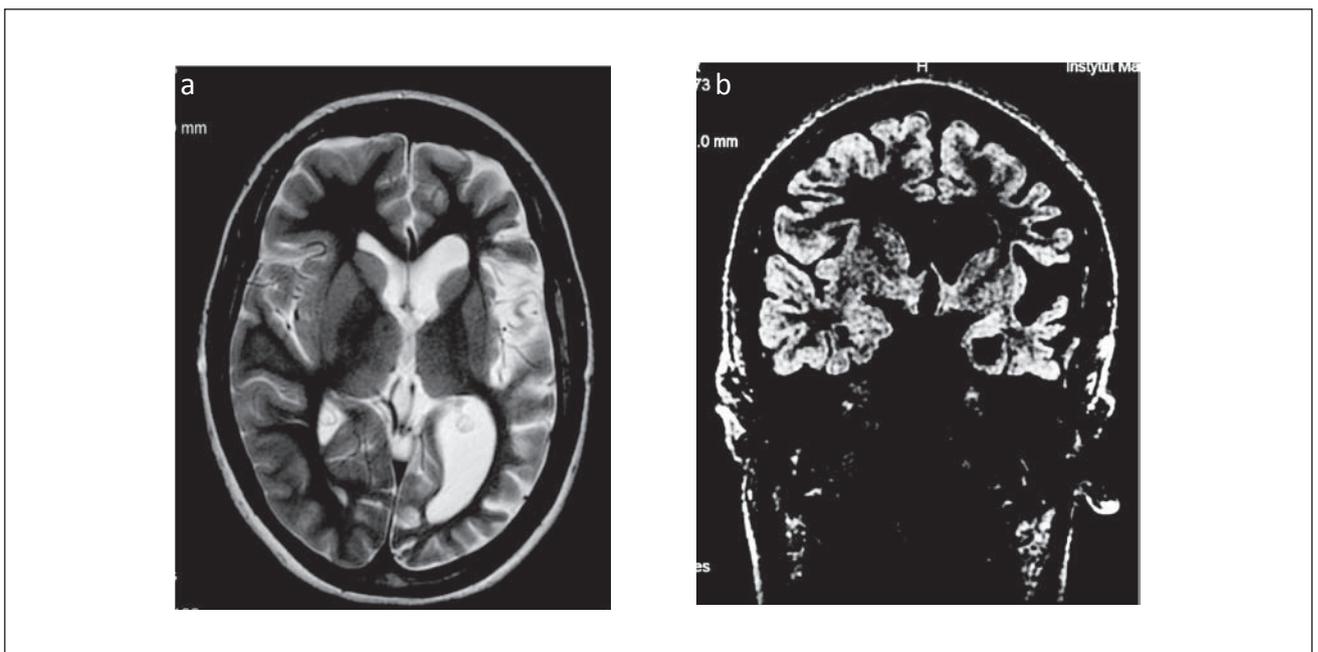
Brain MRI at the age of 12 – progression of the changes. The same slices of the examination as in Figure 1: FSE/T2-weighted image, axial plane (a), CUBE,3D/FLAIR image, coronal plane (b).
